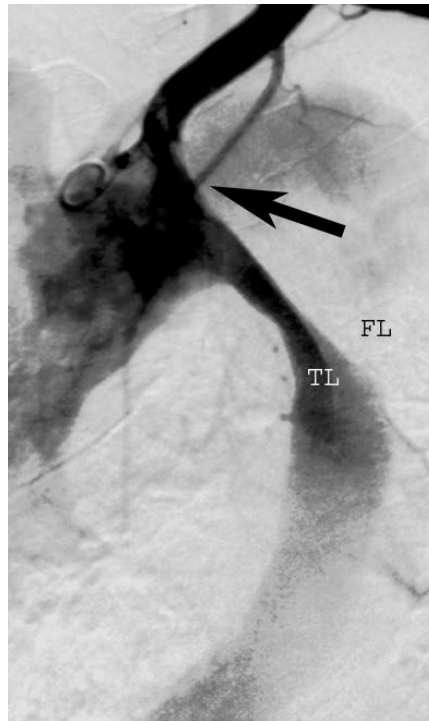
The proximal entry tear for most distal dissections is in the region of the left subclavian artery (*black arrow*). Careful assessment of CT images and angiographic studies will usually render these tears apparent, and amenable to coverage with an endovascular prosthesis. (Reprinted from Greenberg et al. Contemporary management of acute aortic dissection. *J Endovasc Ther.* 2003;10:476–485 by permission of the International Society of Endovascular Specialists.)
